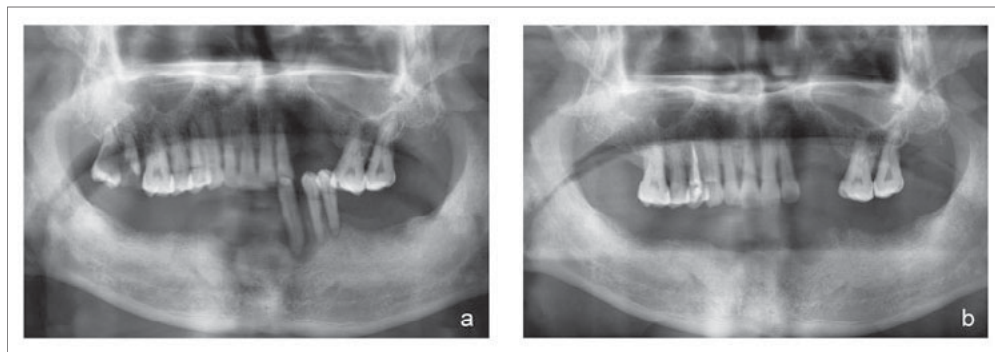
(a) Pretreatment panoramic radiograph; (b) panoramic radiograph of the patient before surgery.
